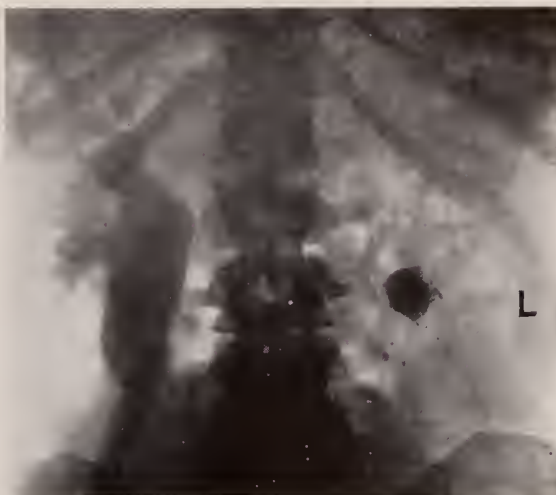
Roentgenogram; hydronephrosis, right (120 cc.), obstructive nephrolithiasis and destructive massive pyonephrosis, left. Pregnancy at about the fifth month.
